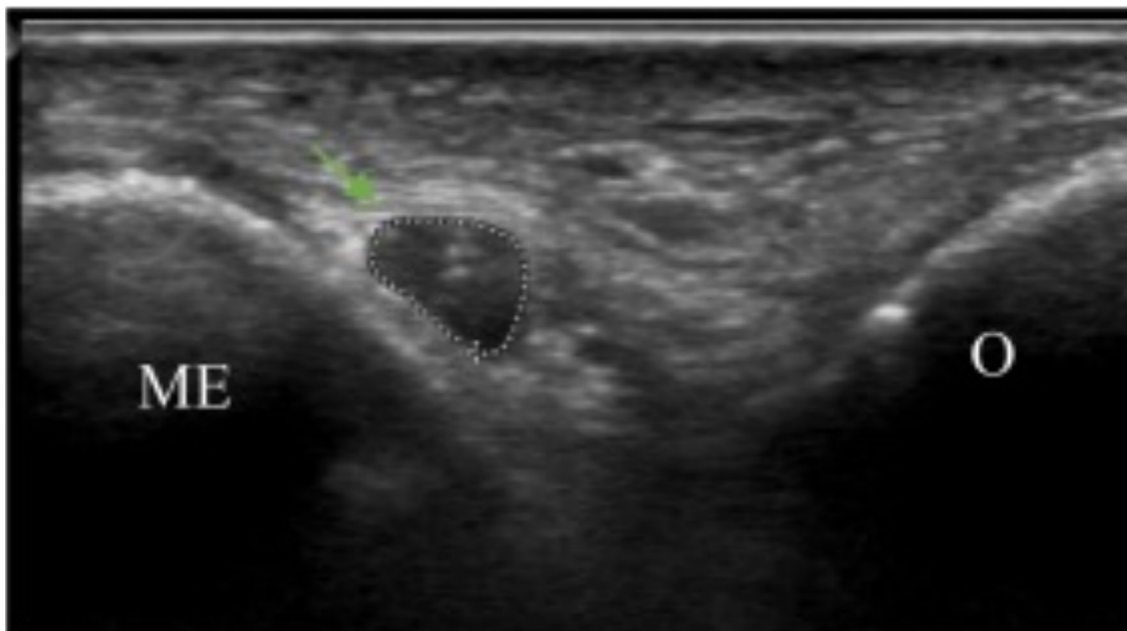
Ultrasound images of ulnar nerve at the level of the medial epicondyle with cross-sectional area calculation. ME=medial epicondyle, O=olecranon. [23]
